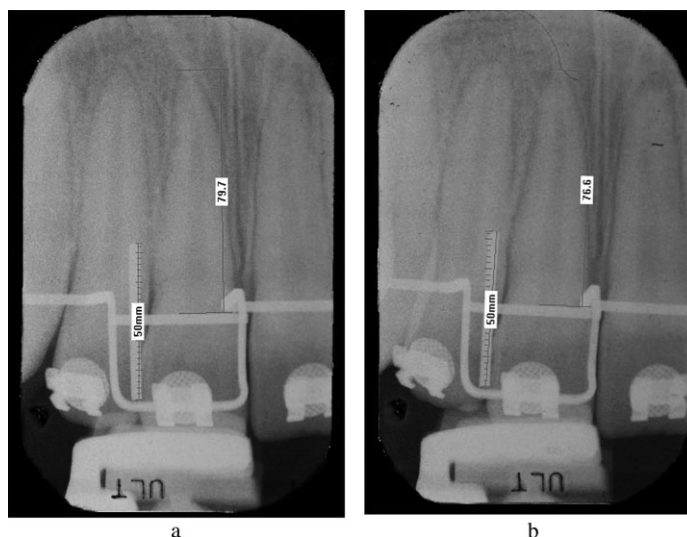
Periapical radiographs at the start (a) and after 6 months (b) of orthodontic treatment.
